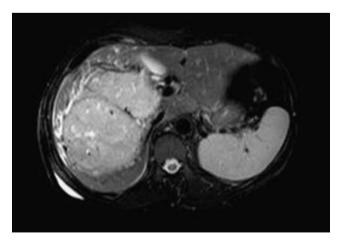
Preoperative Magnetic Resonance Imaging (T2) showing the metastatic hemangiopericytoma developed in the right lobe of the liver.
